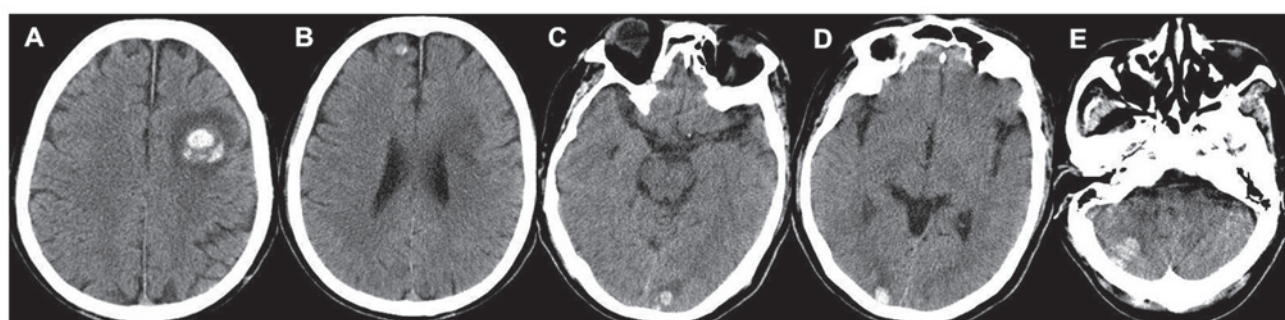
Brain CT. Axial CT showing multifocal intracranial lesions with hyperdensity masses and perilesional edema in (A) the left parietal lobe, (B) the right frontal lobe, (C and D) the bilateral occipital lobes and (E) the right cerebellum.
